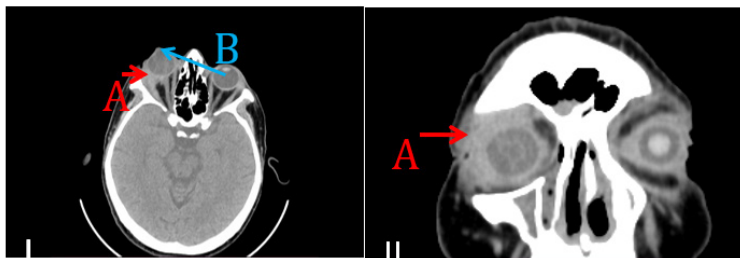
Patient F., 59 years old. CT images of the brain: I - in the axial projection: A - solid formation, with extra- and intracranial location; B - the right eyeball is displaced anteriorly (exophthalmos), the shape is preserved; II - in the coronal projection: A - solid formation
